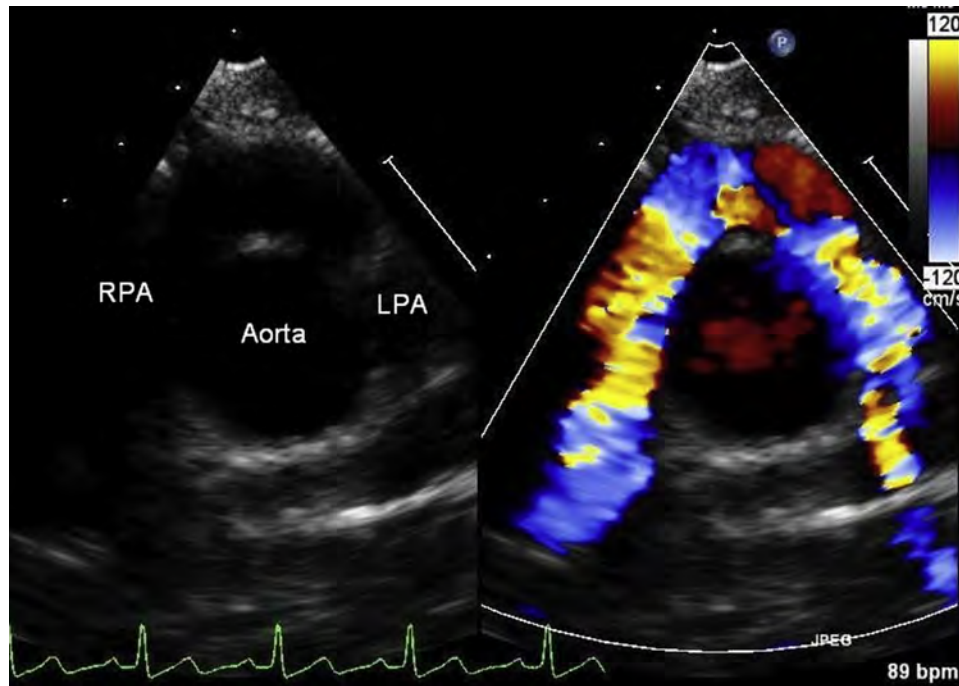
High parasternal view in color-compare mode demonstrates the anterior relationship of the branch pulmonary arteries to the aorta after the LeCompte maneuver. *LPA*, Left pulmonary artery; *RPA*, right pulmonary artery.
